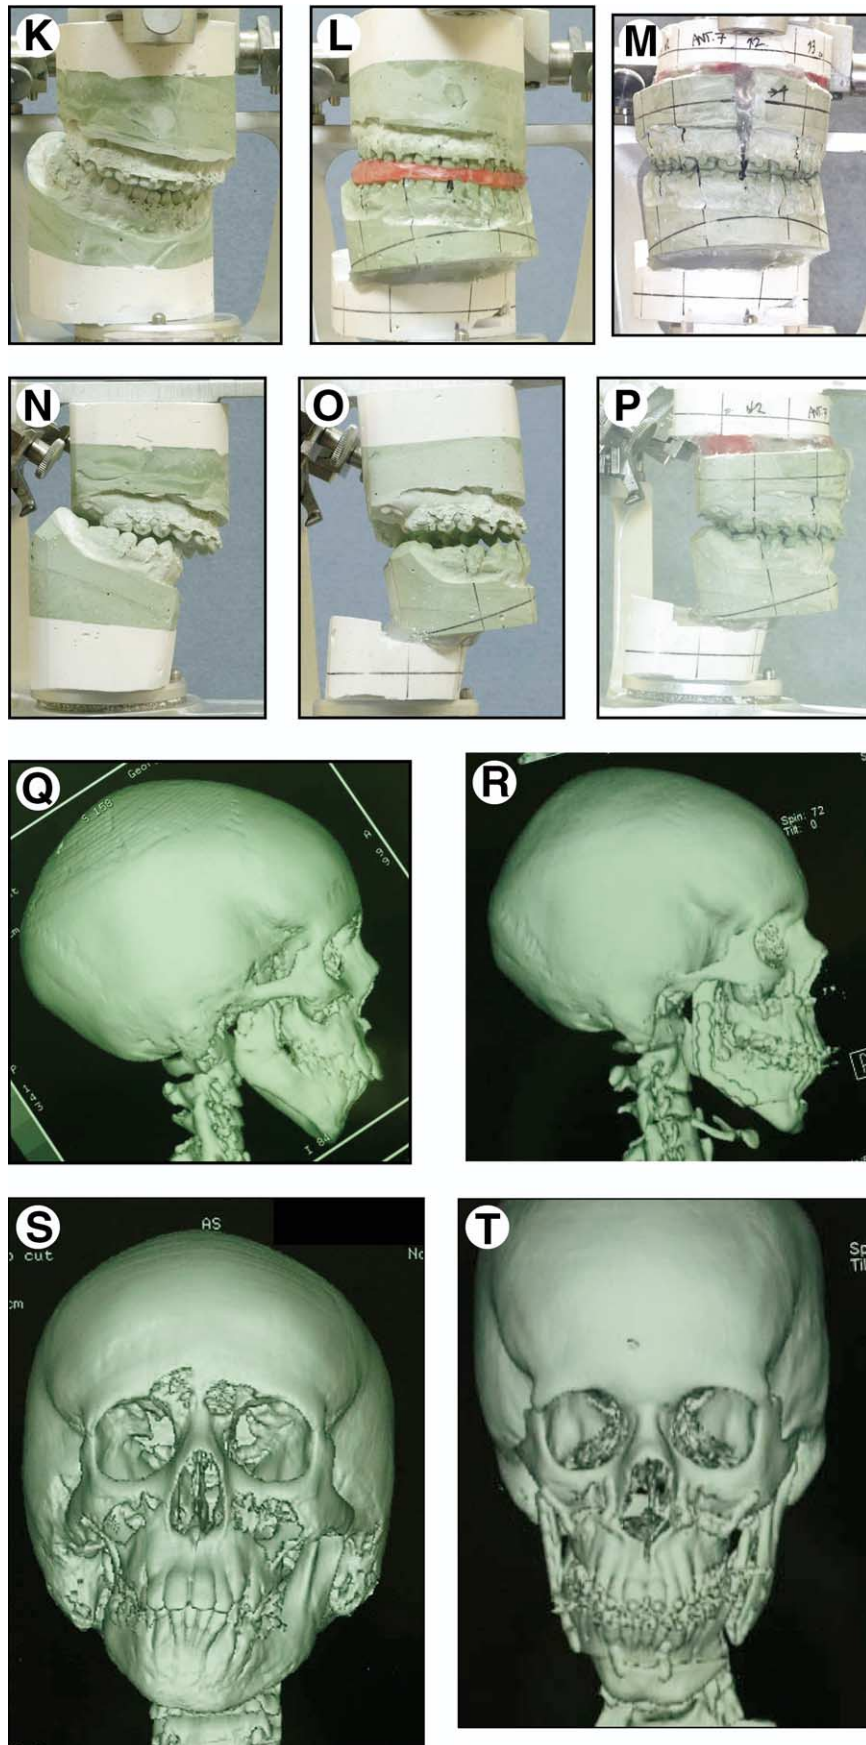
(cont'd). K–M, Articulated dental models (frontal view) demonstrating stages of reverse model surgery planning. N–P, Lateral views of articulated dental models demonstrating reverse model surgery planning. Q, R, Lateral craniofacial CT scans before and after reconstruction. S, T, Frontal craniofacial views before and after reconstruction.
